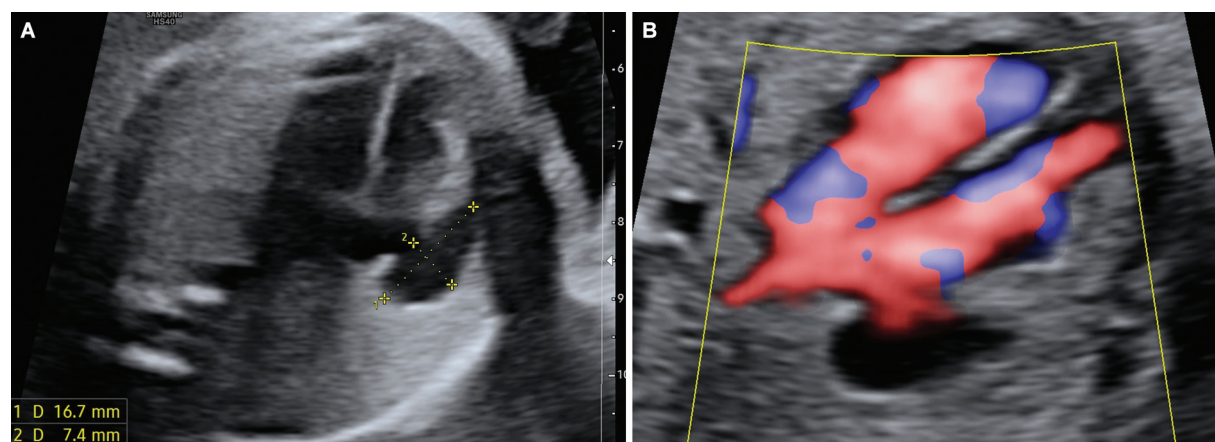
Fetal ultrasound at 22 weeks' gestation. Right atrial appendage aneurysm (*) on different cardiac views. (A) Note the thin wall of the aneurysm (yellow lines) and the size of the abnormal chamber compared with the atria and ventricles. (B) Using color Doppler, the same cystic structure with blood flow is observed.
